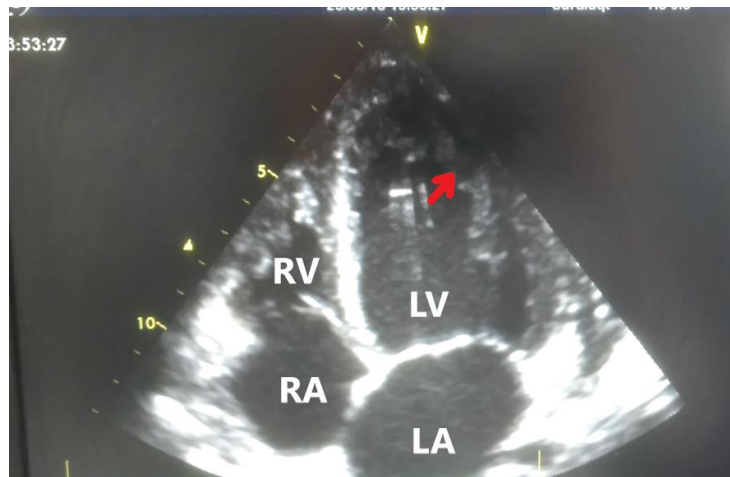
Four chamber view echocardiography showing excentric hypertrophy of the left ventricle (LV). Prominent ventricular trabeculations and deep intertrabecular recesses are seen (red arrow). RV: right ventricle; LA: left atrium; RA: right atrium
